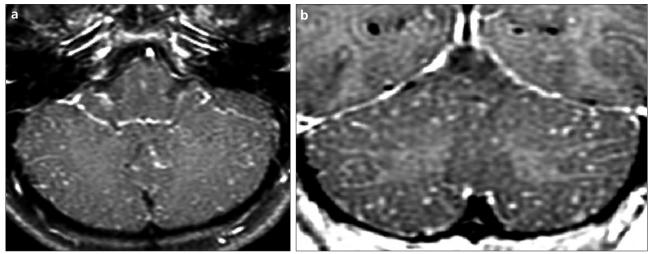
a, b. Axial (a) and coronal plane (b) contrast-enhanced T1-weighted MR images show unusual leptomeningeal enhancement in the cerebellar hemispheres that was located predominantly peripherally.
